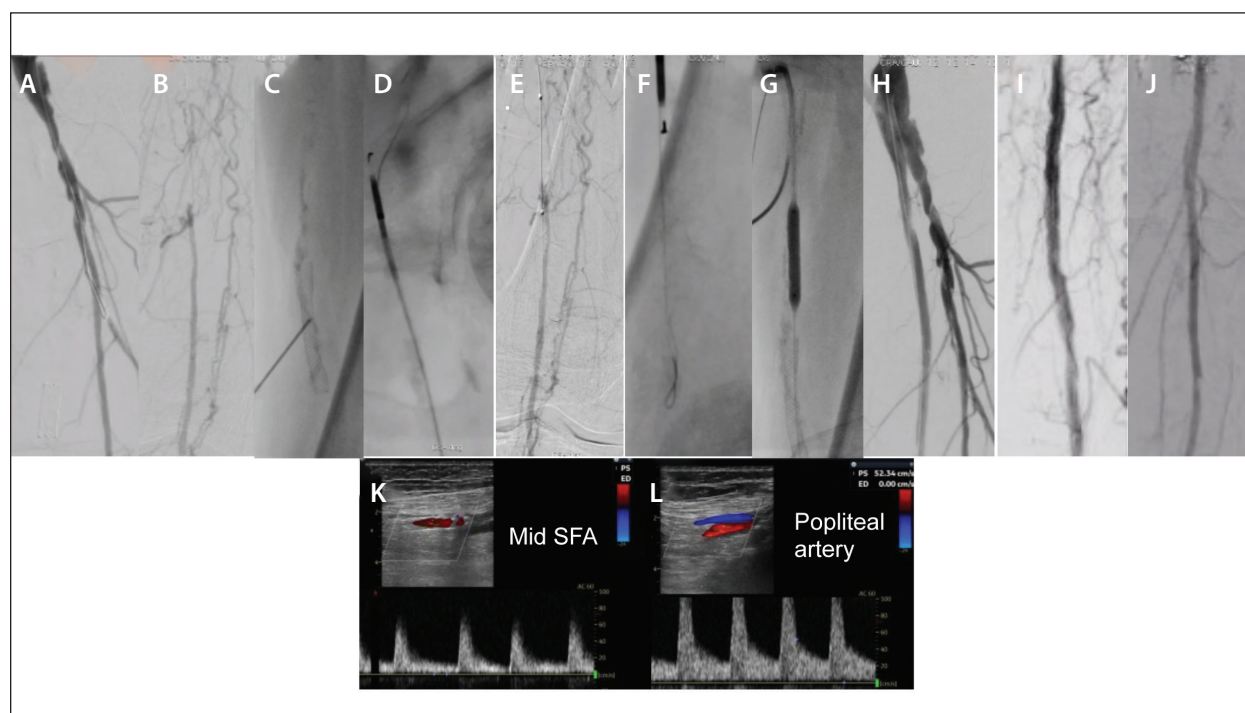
DSA images showing occlusion of the bypass graft and native femoral artery, with reconstitution in the popliteal artery (A, B). After retrograde puncture of an occluded SFA stent (C) and insertion of a 6-F sheath, an OUTBACK™ Elite Re-Entry Catheter enabled re-entry to the CFA true lumen from retrograde (D). Crossing the CTO from antegrade was then attempted and also required use of the re-entry catheter (E, F). After high-pressure balloon angioplasty (G) and placement of bare-metal stents, antegrade flow was restored in the SFA (H-J). Duplex ultrasound imaging (K, L).
